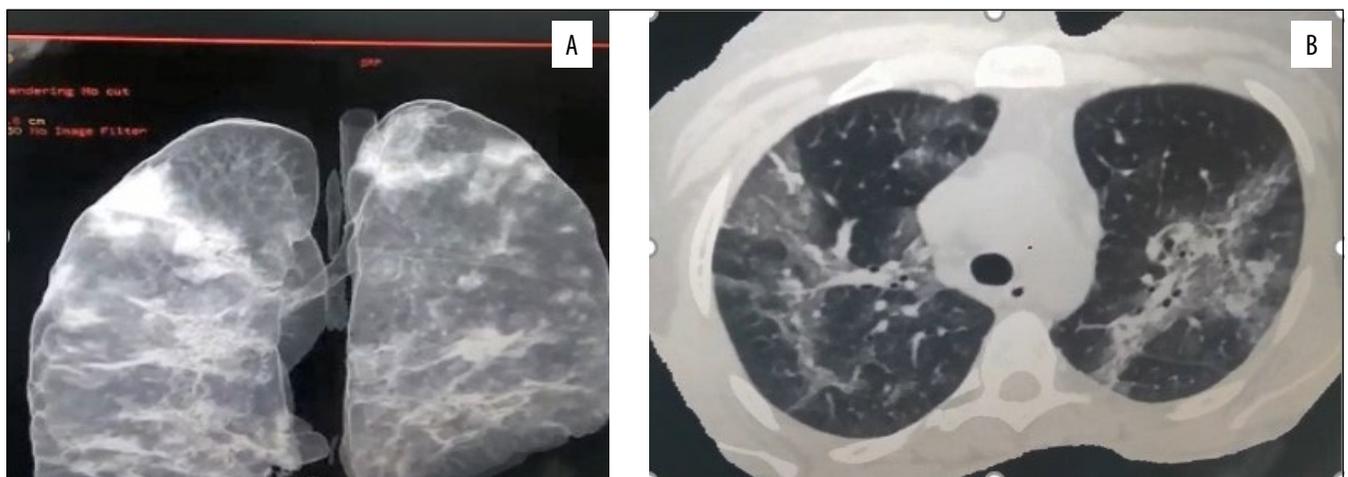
Lung CT scan of the patient N. (day 32 of illness), demonstrating the signs of viral bilateral pneumonia with coalescent foci, with involvement of 50-75% of the lung parenchyma (stage 3 [12]). (A) 3D reconstruction; (B) axial plane.
